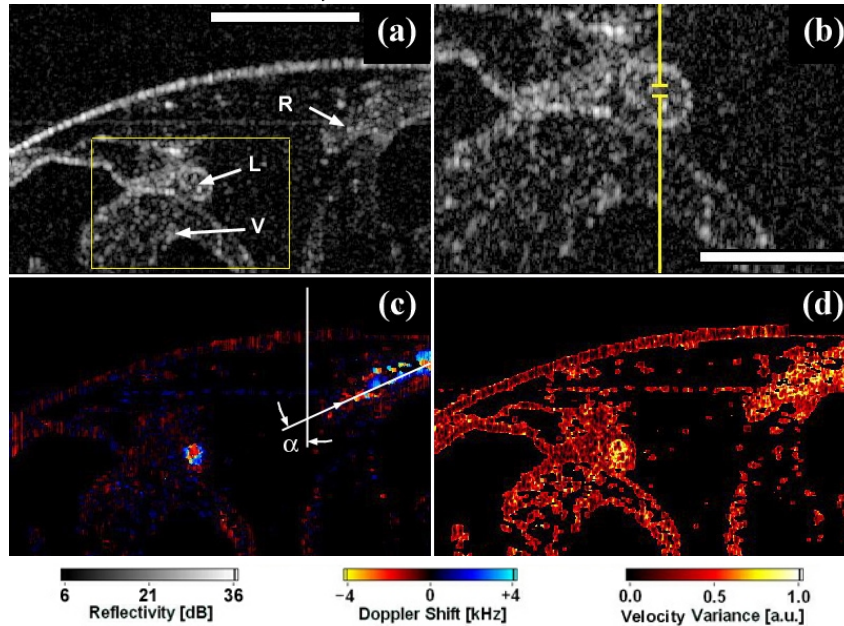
DOCT video [480 kB with audio] of a stage 47 *Xenopus* tadpole, imaging the left and right aortic branches (L and R), acquired at 8 fps. (a) Structural (B-mode) video of the aortic branches cross-section. Notice a smaller vessel (V) in the video. Bar = 500 μm . (b) $2\times$ zoom of the yellow rectangular region in (a), showing the micro-structure of L. The break in the yellow line indicates the location from which Doppler spectrum information is collected and encoded into audio format (see Fig. 4), demonstrating the velocity distribution within L. Bar = 250 μm . (c) Color-Doppler video, showing the corresponding velocity map in the cross-section. Notice the low noise background, and the pulsatile blood flow in L and R. The Doppler angle (α) is estimated to be $\sim 63^\circ$ for R. The small blood vessel (V) is much better visualized in the color-Doppler mode, allowing estimation of its diameter to be less than 70 μm . Systole occurs during the 4th and 5th frames, where the velocity gradients in R are visible, and the peak Doppler shift is ~ 9 kHz considering aliasing effects. (d) Velocity variance video, showing the increased variance of the blood flow within L and R. Each individual image was recorded at 450×508 pixels, and re-sampled into 256×160 pixels for video compression. The faint horizontal line in (a), (c), and (d) was an artefact probably due to multiple-reflection.
